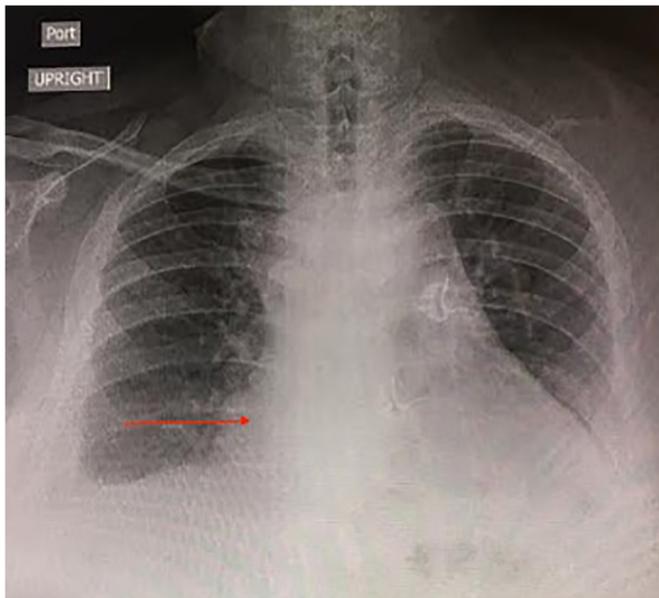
Chest x-ray after pericardiocentesis showing significant decrease in size of cardiomegaly.
